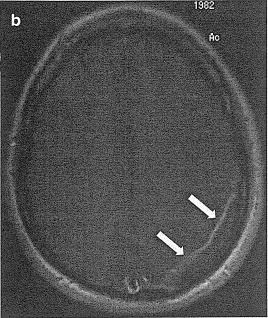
T1-weighted magnetic resonance image (MRI) with gadolinium enhancement showing enhanced left posterior dura mater and epidural abscess. *Arrows* indicate epidural abscess (a sagittal view, b axial view)
